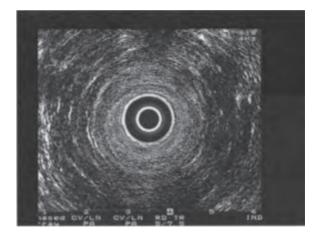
Normal ultrasound examination of the anal canal. The internal sphincter is seen as a hypoechoic (black) ring, and the external sphincter as an echogenic (white) ring.
